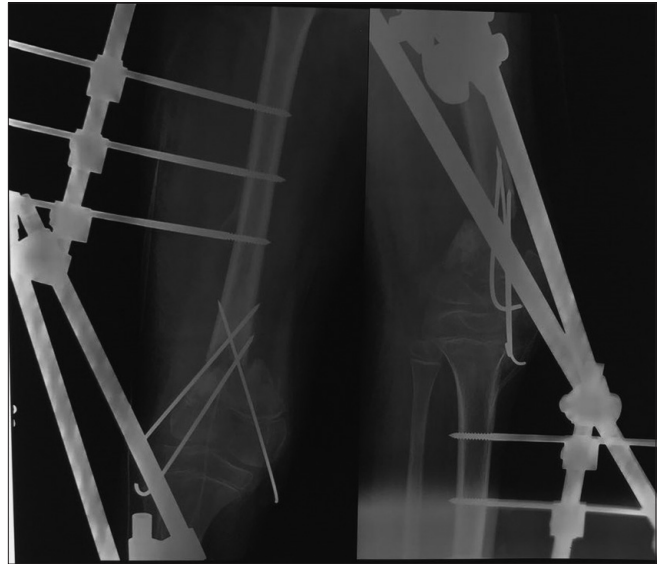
Radiographs of distal thigh with knee joint showing the use of external fixation with K-wires in the treatment of an open fracture of the distal femur for soft-tissue loss
